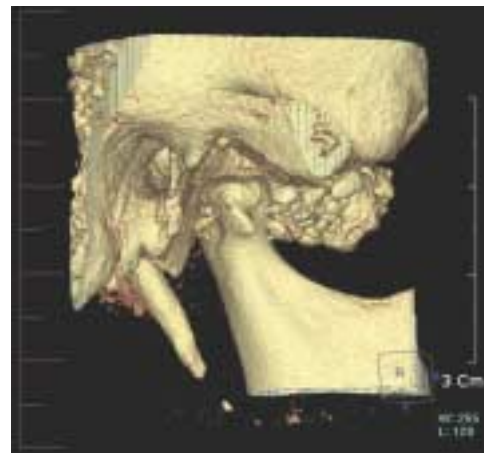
multiple calcification in cone beam CT.
